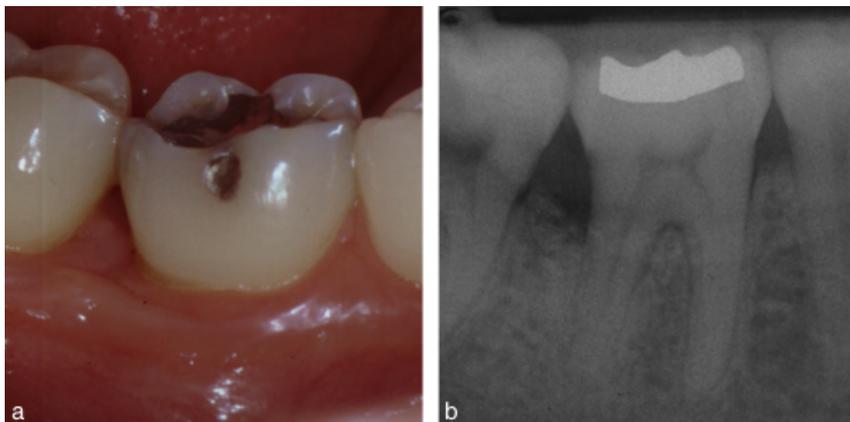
(a) The clinical result 1 year after treatment. (b) Resolution of the defect with radiographic bone-level gain and slight crestal resorption is observed in the X-ray 1 year after treatment.
